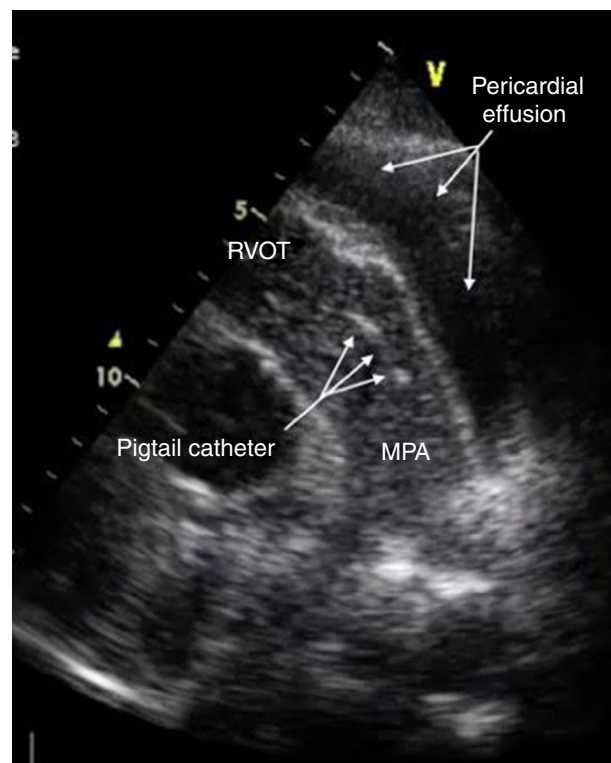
Contrast injection in parasternal short-axis echocardiographic view showing the catheter in the main pulmonary artery. MPA: main pulmonary artery; RVOT: right ventricular outflow tract.
